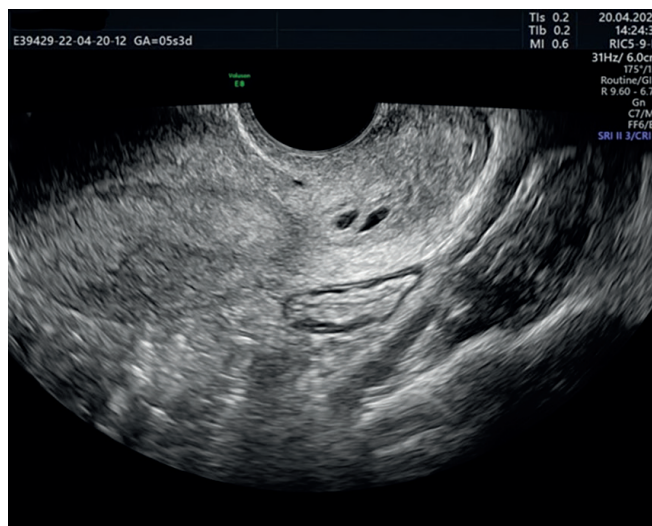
Ultrasound image of cervical twin pregnancy.
